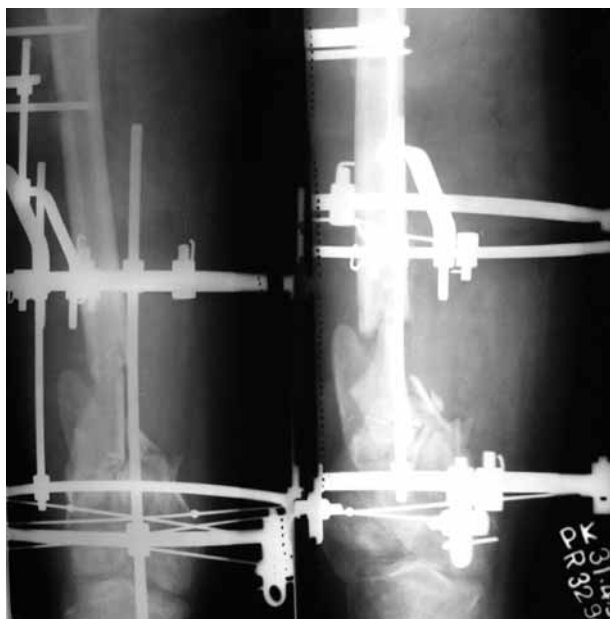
Intraoperative AP & lateral radiographs
